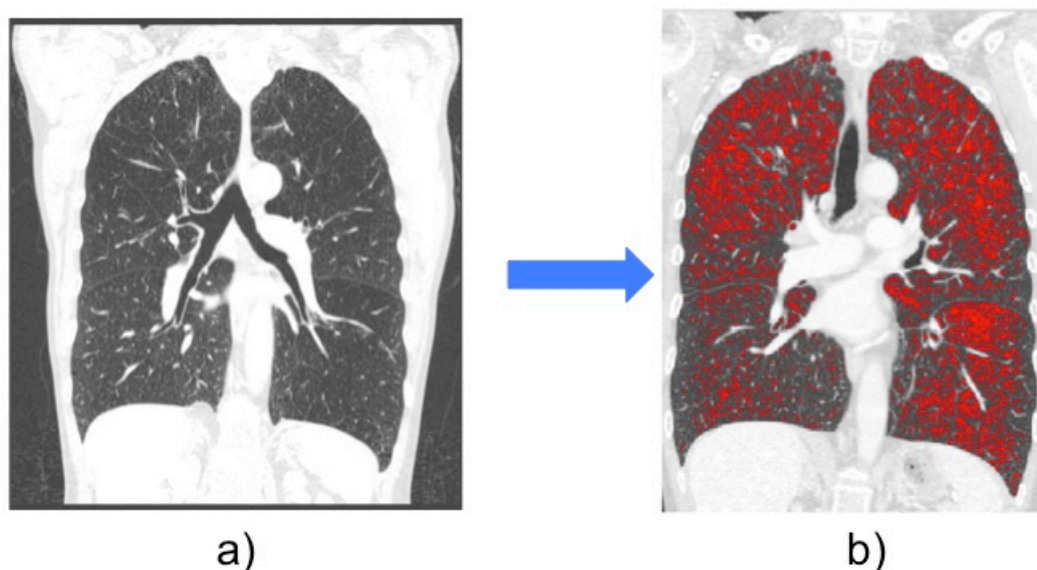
Method used to quantify lobar percentage emphysema from QCT. a) Coronal CT chest in lung windows. b) PTK determines the percentage of lung tissue with attenuation below the threshold -950 HU (red areas) corresponding to emphysema.
